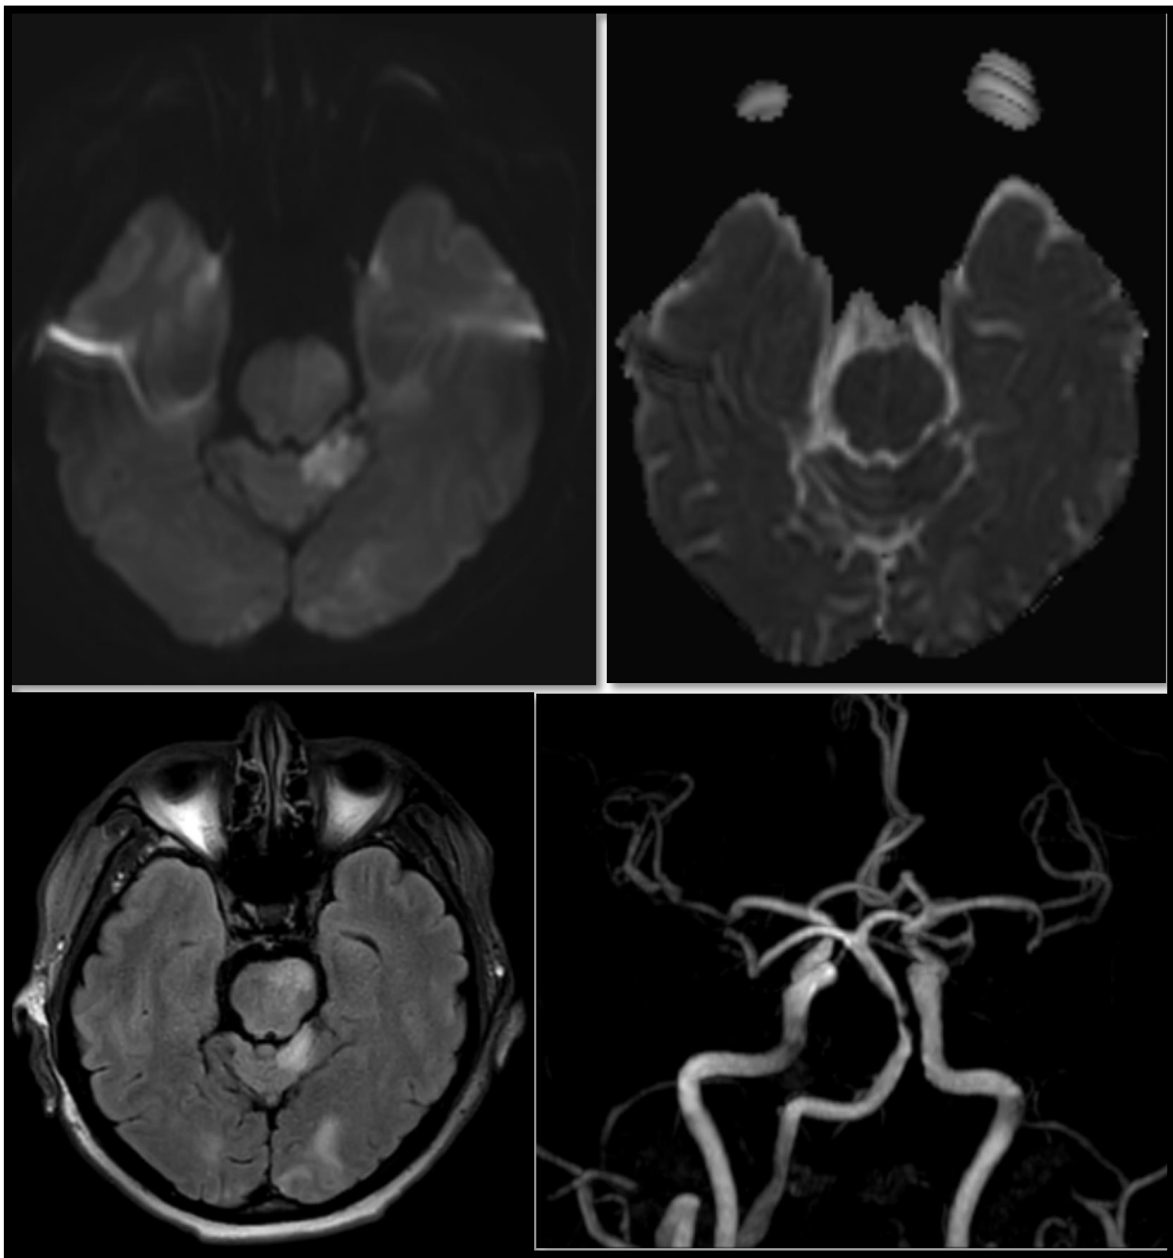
MRI evaluation showed resolution of the cerebral infarcts with patent flow in the treated BA.
